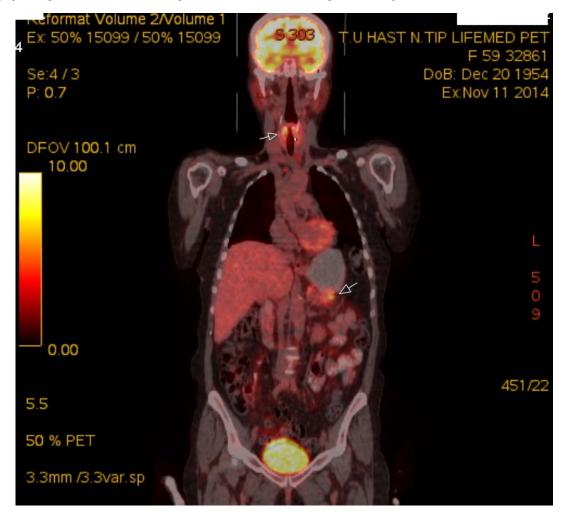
¹⁸F-FDG PET/CT images; globally increased FDG uptake at the thyroid region, increased FDG uptake at the upper tracheal lymph node, soft tissue lesion at pancreatic tail and peripancreatic lymph node
